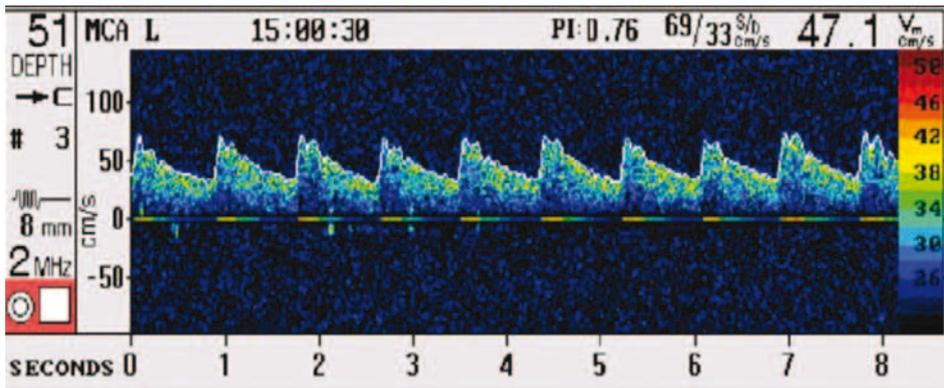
Image of an adequate transcranial Doppler ultrasonography signal of the MCA with a mean velocity of 47.1 m/s, peak-systolic flow velocity of 69 cm/s, and an enddiastolic flow velocity of 33 cm/s.
